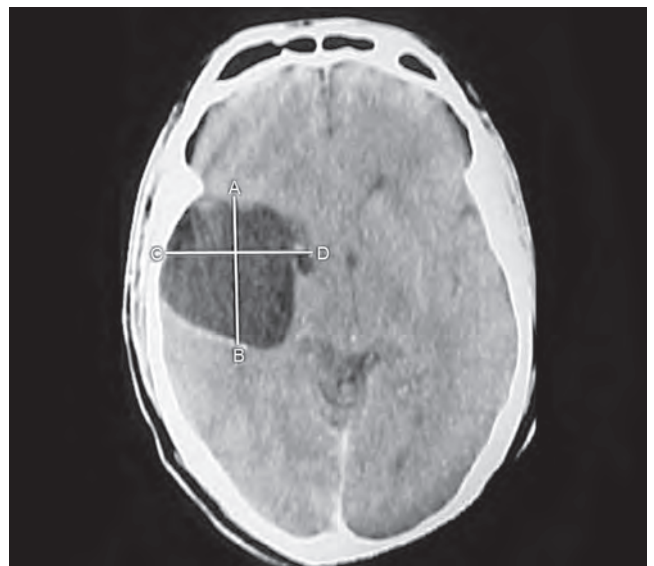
CT scan of the brain showing epidermoid in the right Sylvian fissure
